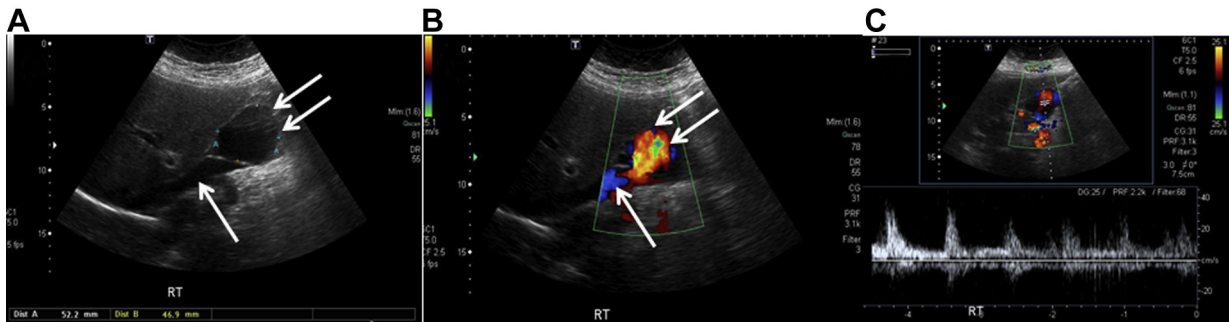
Abdominal ultrasound (A) B-mode imaging and (B) color-flow imaging demonstrates a vascular structure anterior to the aorta and inferior vena cava (IVC). C, Duplex demonstrates a “ying-yang” appearance on Doppler flow. The *single arrow* points to the IVC, and the *double arrows* point to the IVC aneurysm (IVCA).
